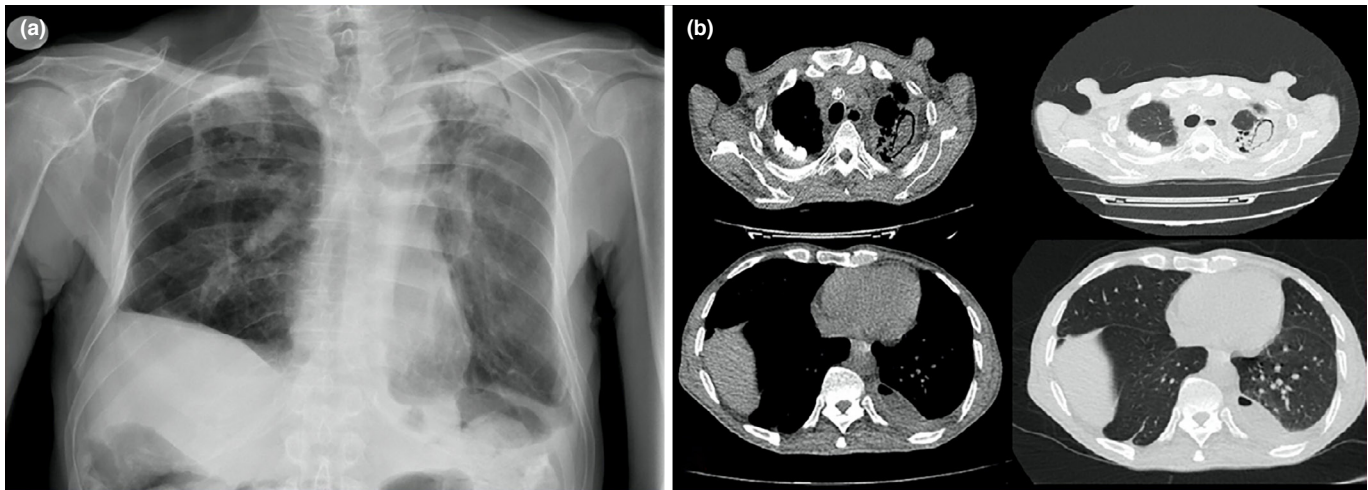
(a) Chest radiography shows bilateral apical sequela densities and a density in the left apex suggestive of an aspergilloma. (b) Thoracic computed tomography (CT) reveals traction bronchiectasis in the left upper lobe, a cavitary lesion with a suspected fungus ball (aspergilloma), bilateral parenchymal sequelae, right pleural calcification, and pleural effusion in the left pleural space
